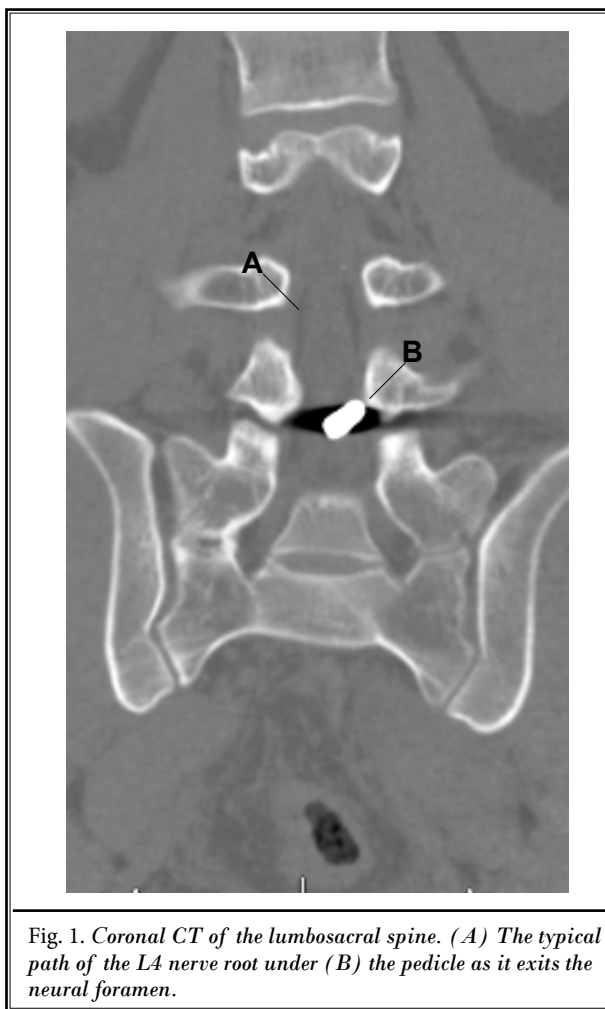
Coronal CT of the lumbosacral spine. (A) The typical path of the L4 nerve root under (B) the pedicle as it exits the neural foramen.
